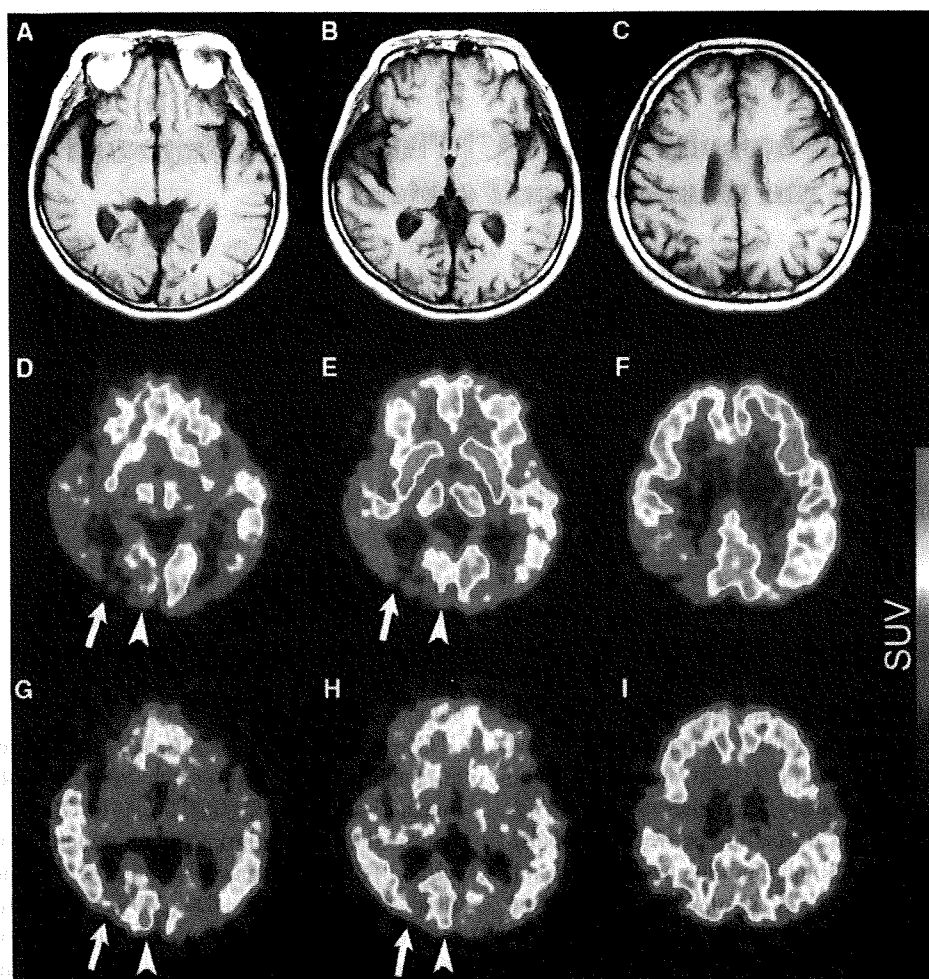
Transverse T1-weighted MRI sections (a–c), PET with [^{18}F] FDG (D–F) and PET with [^{11}C] PIB (g–i) of the patient. MRI showed the absence of cerebral infarction and atrophy (a). The medial region including the calcarine cortex, (d, e, g, h arrowhead) showed
